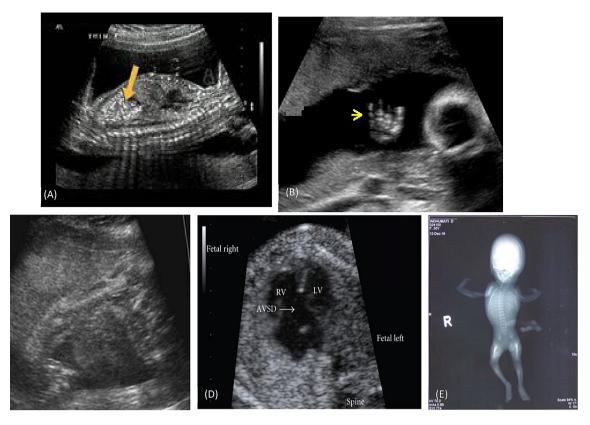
The ultrasound images (a); (b); (c); (d); Infantogram (e)
